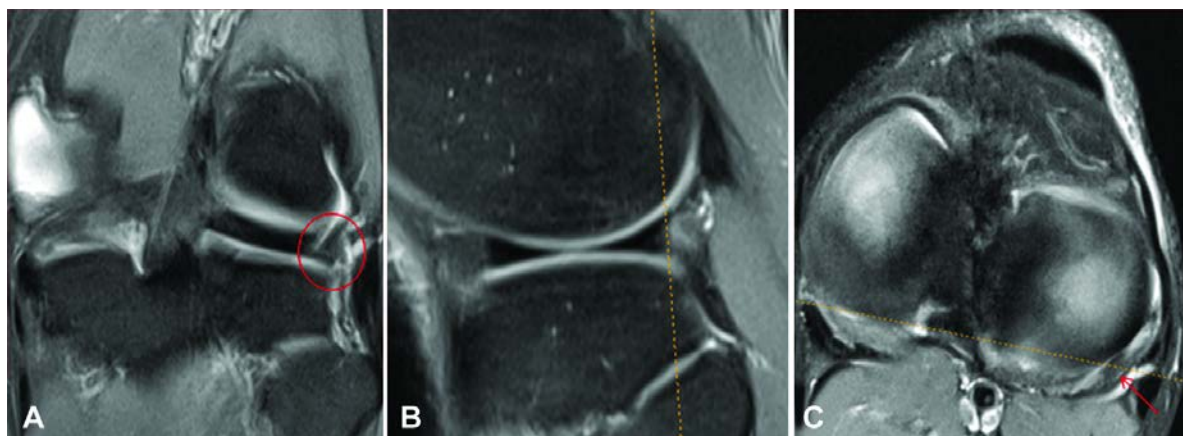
MRI scans of the left knee in a 26-year-old patient F. showing: A – coronal view demonstrating high MRI signal at the edges of posterior horn of the lateral meniscus being susceptible of a tear; B – sagittal view demonstrating homogenous hypointense MRI signal; C – transverse view demonstrating hyperintense MRI signal being typical for fluid at the popliteal tendon
